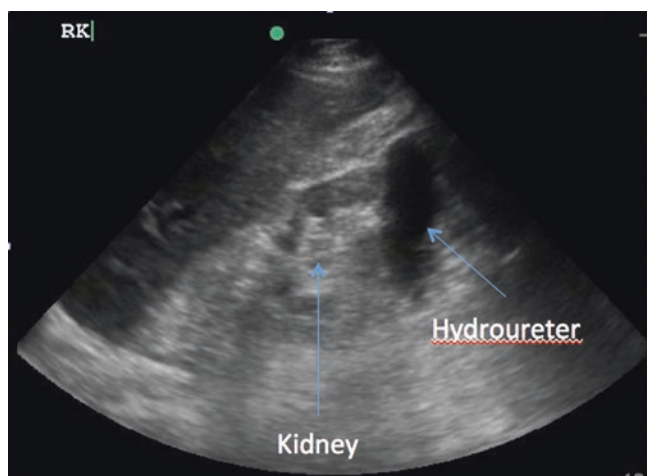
Bedside ultrasound for suspected renal disease. Point-of-care sonography of the kidneys shows the hydronephrer as hypoechoic (black) fluid-filled area next to the kidneys in this longitudinal image. This image was obtained in a young female with sepsis and flank pain. Subsequent CT scan confirmed an obstructing stone prompting urologic intervention. See also Video 37.12
